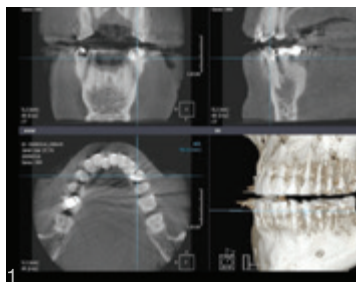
Case #1 cone beam computerized tomography showing infection apically for tooth #21.
